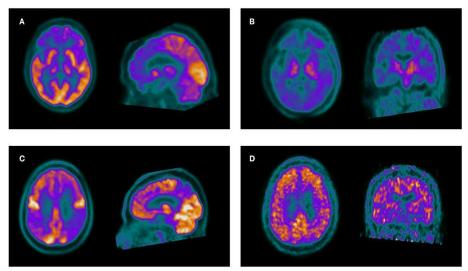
¹⁸FDG PET in the axial and sagittal plane (A) shows frontal hypometabolism which is suggested on FTD. ¹¹C-PIB PET in the axial and coronal plane (B) are negative to the amyloid accumulation, which is confirmed by FTD. ¹⁸FDG PET (C) shows hypometabolism in the posterior parietal lobe and precuneus which points to AD. ¹¹C-PIB PET (D) confirms AD. From the Front. Neurol., 04 May 2021 | https://doi.org/10.3389/fneur.2021.630958
